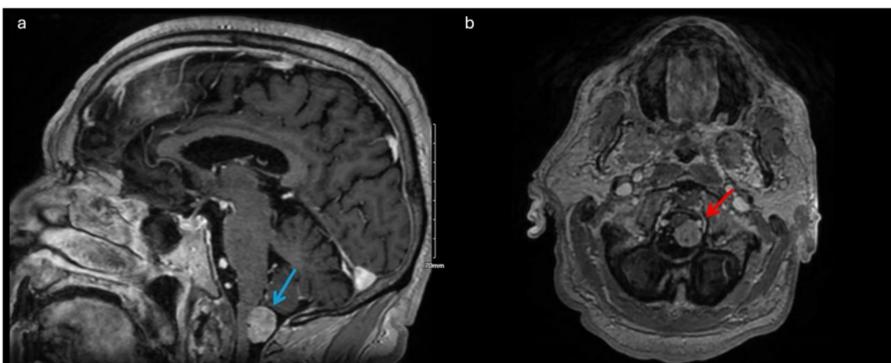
Preoperative T1-weighted postcontrast MRI (sagittal A, axial B) demonstrating a well-circumscribed, homogeneously enhancing intradural extramedullary mass compressing the cervicomedullary junction (blue arrow) and left vertebral artery (red arrow)
